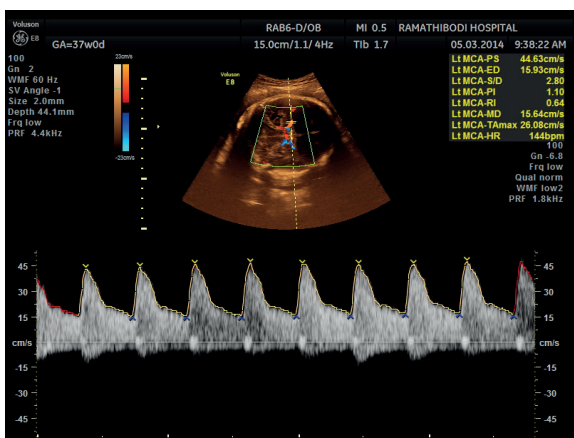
Measurement of middle cerebral artery Doppler.
